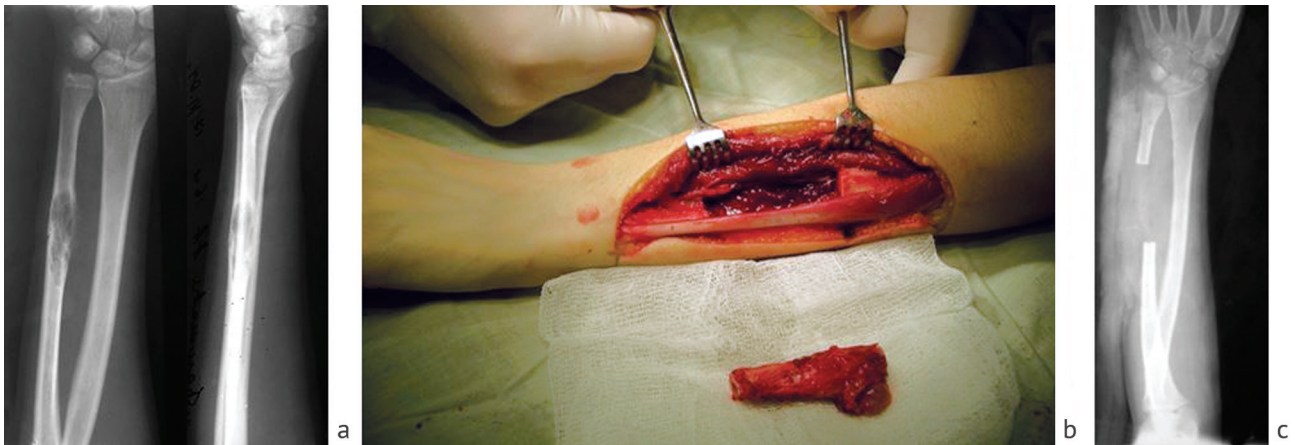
Radiographs of the left forearm before surgery (a); b, c photos and radiographs at the stages of the operation
